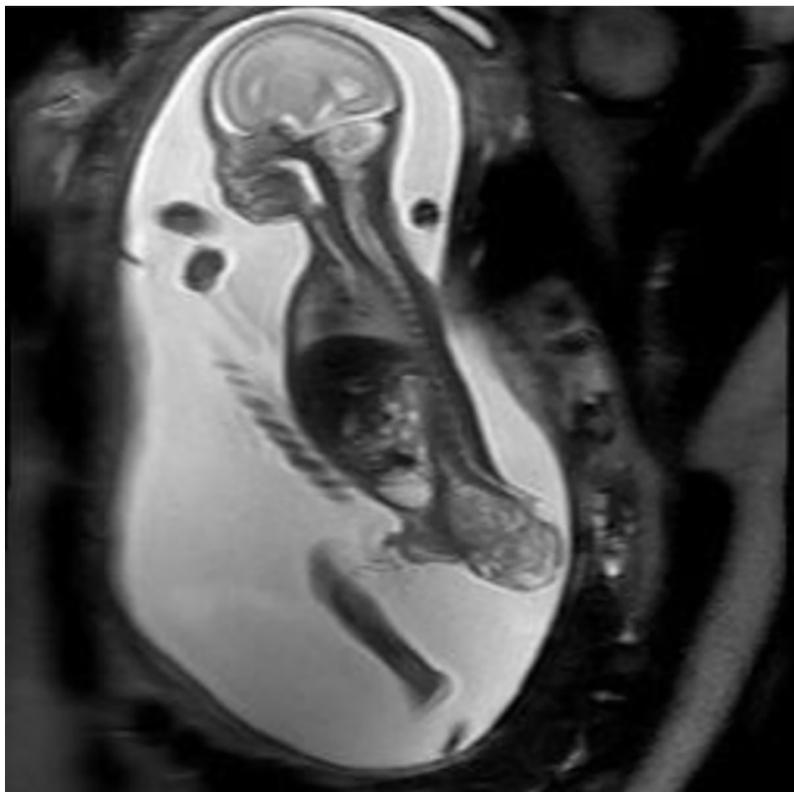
Magnetic resonance imaging revealed a heterogeneous cystic sacrococcygeal teratoma measuring 47×46×30 mm, located below the bladder.
